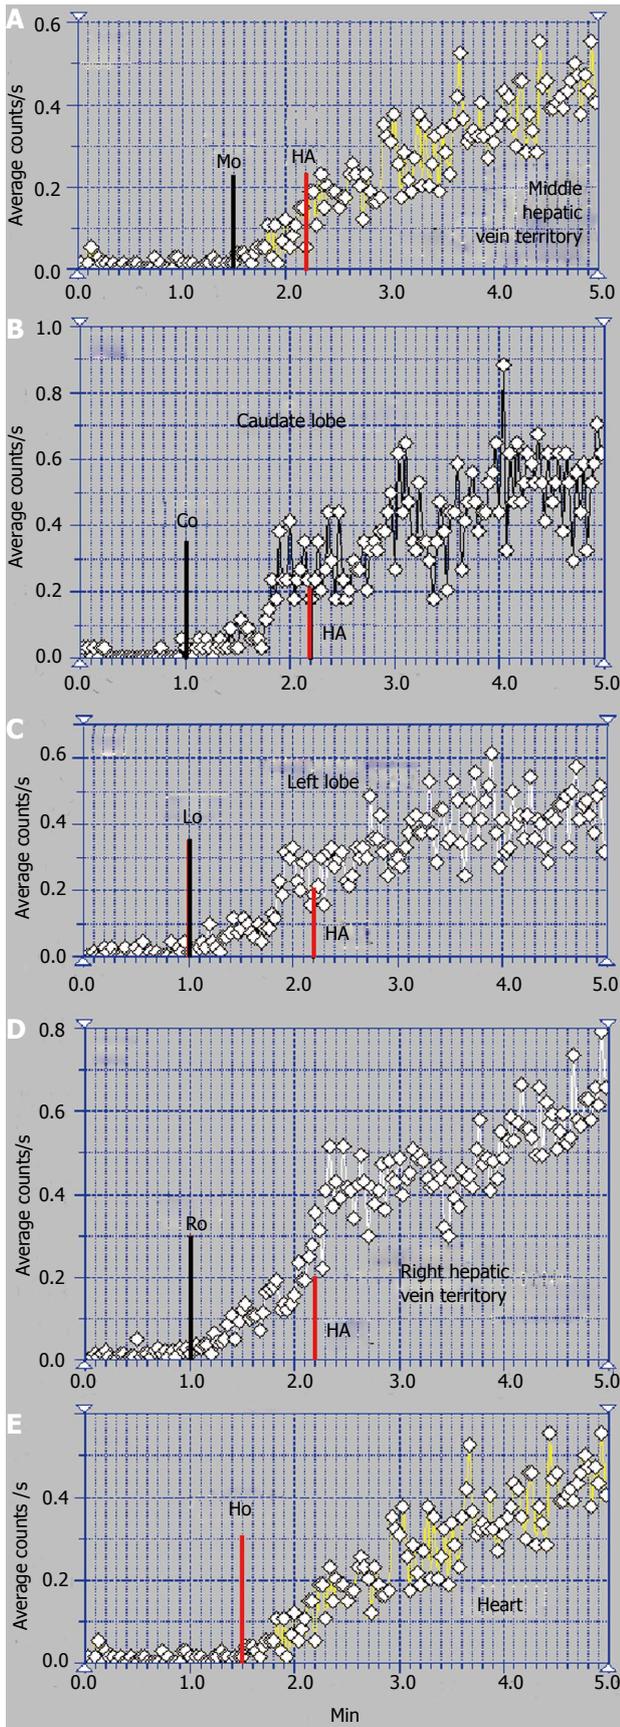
Per-rectal portal scintigraphy in Budd-Chiari syndrome with obstruction of the middle hepatic vein. A: Curve on the territory drained by the middle hepatic vein; B: Caudate lobe curve; C: Left lobe curve; D: Curve on the territory drained by the right hepatic vein; E: Heart curve.
